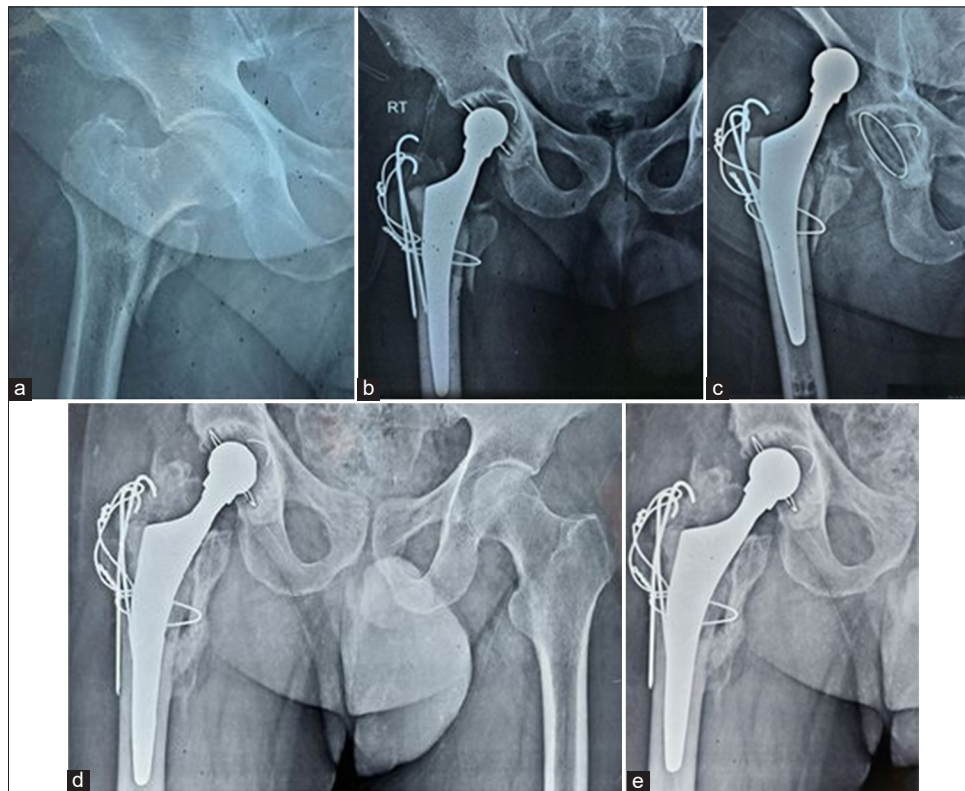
(a) A pre-operative radiograph of a 75-year-old male with recent right unstable intertrochanteric femur fracture. (b) Post-operative radiograph showing cemented total hip arthroplasty with trochanteric fixation with K-wires. (c) Two weeks post-operative the patient fell to the ground and presented with hip dislocation. (d) 6-month follow-up after closed reduction showing well-fixed component, no signs of loosening, fully united trochanter. (e) One-year follow-up showing well-fixed component, no signs of loosening, and a fully united trochanter.
